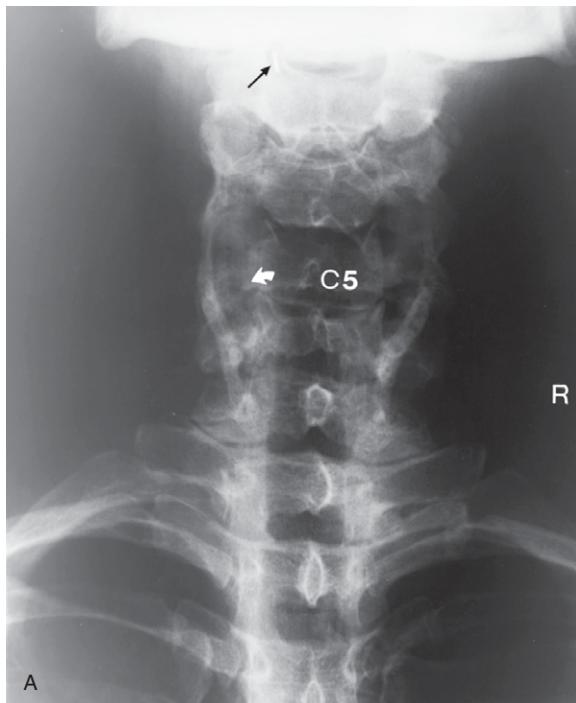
(A) Cervical spine anteroposterior plain X-ray image showing the clip (black arrow) in the left suboccipital region where the C2 neurectomy was performed and the C2 nerve was clipped and divided. C5 = fifth vertebra. White curved arrow shows the osteophyte projecting from the left uncovertebral joint toward the vertebral artery in the transverse foramen. R = right side of patient. (B) Cervical spine neutral lateral plain X-ray image showing thinning at the C5–6 disc level and particularly at the C6–7 level. Note the neurectomy clip (white arrow). 3 = third vertebral body; 6 = sixth vertebral body.
